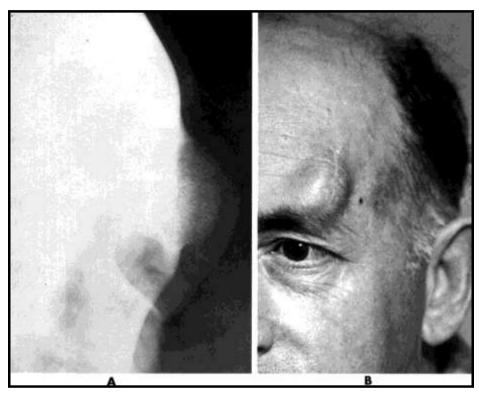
Hemangioma of bone: Radiographic and gross features. A, Hemangioma of frontal bone with prominent striations of bone trabeculae traversing lesion. B, Clinical photograph of lesion shown in A⁽¹²⁾.
